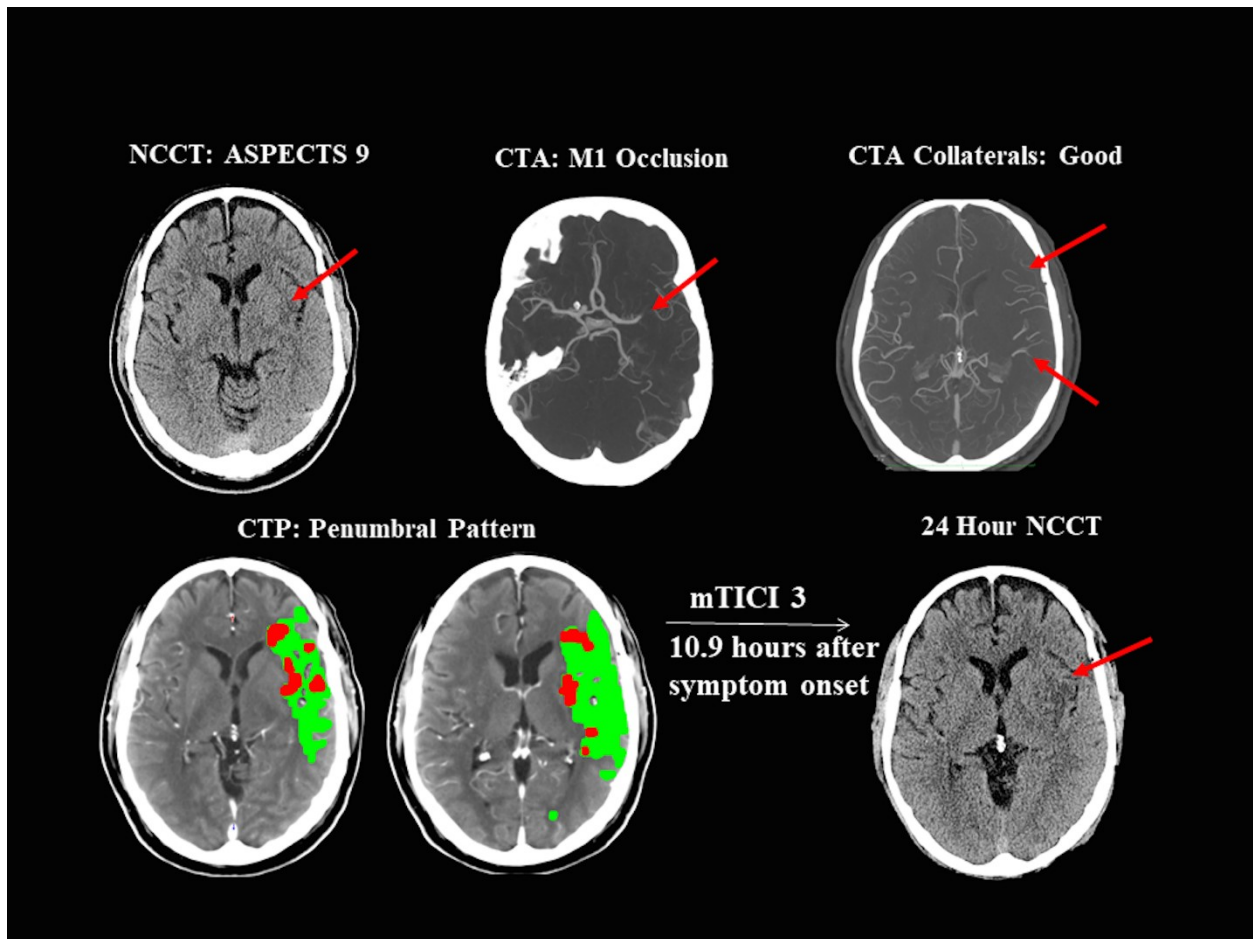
Target Mismatch Patient. Acute and 24 hour follow-up CT imaging in a 59 year old man treated with tPA, followed by endovascular therapy that resulted in full recanalization and modified Thrombolysis in Cerebral Infarction (mTICI 3) flow 10.9 hours after onset. Baseline non-contrast CT (NCCT) ASPECTS was 9. CT angiography (CTA) demonstrated good collaterals. CT perfusion (CTP) demonstrated a penumbral pattern (core (red) =18.5 mL; penumbra (green) =44.4 mL; mismatch =3.4). Follow-up non-contrast CT demonstrated minimal infarct growth (24 hour infarct volume=20.0 ml), and the day 90 modified Rankin Scale score was 2.
